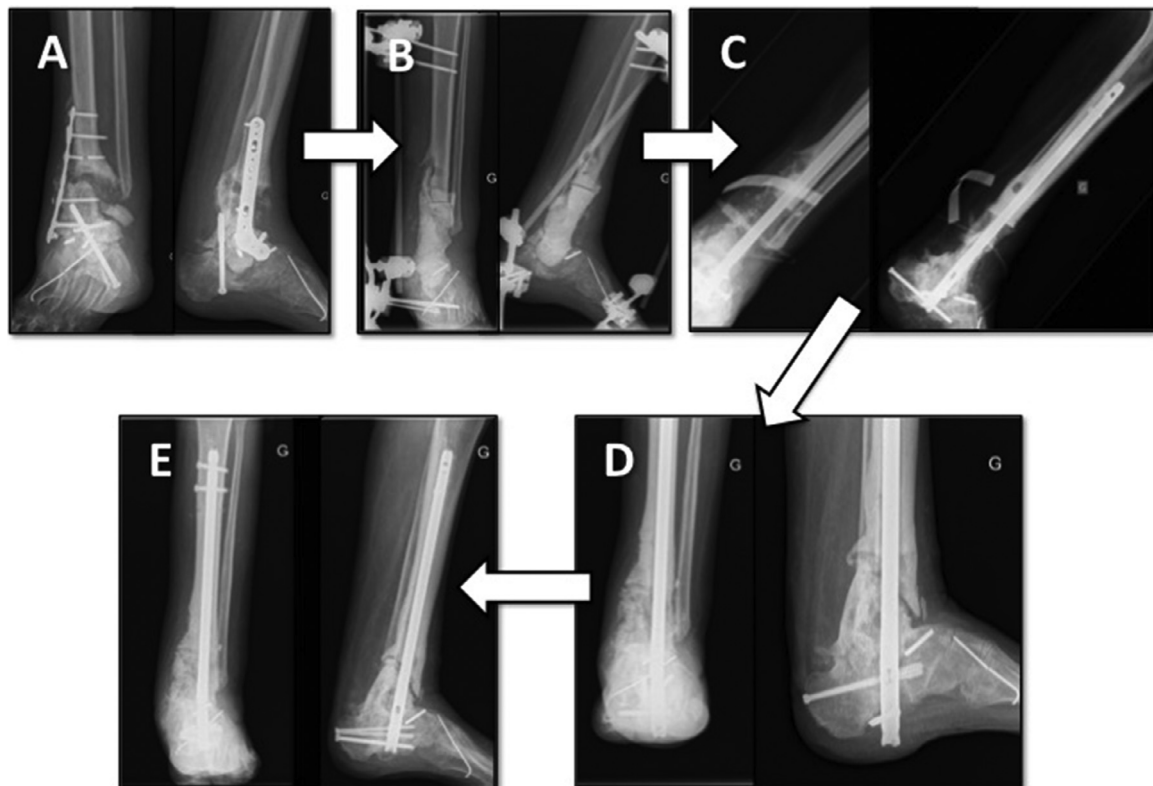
Failure of the use of BAG in an induced membrane because of the recurrence of the infection in a left distal tibial bone defect (A: pre-operative X-Rays, B: First stage X-Rays, C: Second stage X-Rays 21 months after the first stage, D: X-Rays 3 months after BAG implantation, E: X-Rays at last follow-up of 2,5 years).
